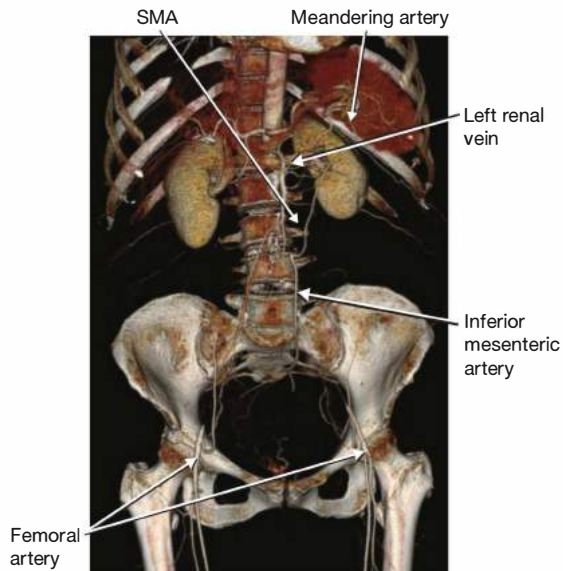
• CTA identifying flush aortic occlusion at the level of the renal arteries, just deep to the left renal vein, with reconstitution of both common femoral arteries. Note the collateral network from the superior mesenteric artery (SMA), through the meandering artery to the inferior mesenteric artery (IMA), and into the pelvis, which has no hypogastric arterial flow.
